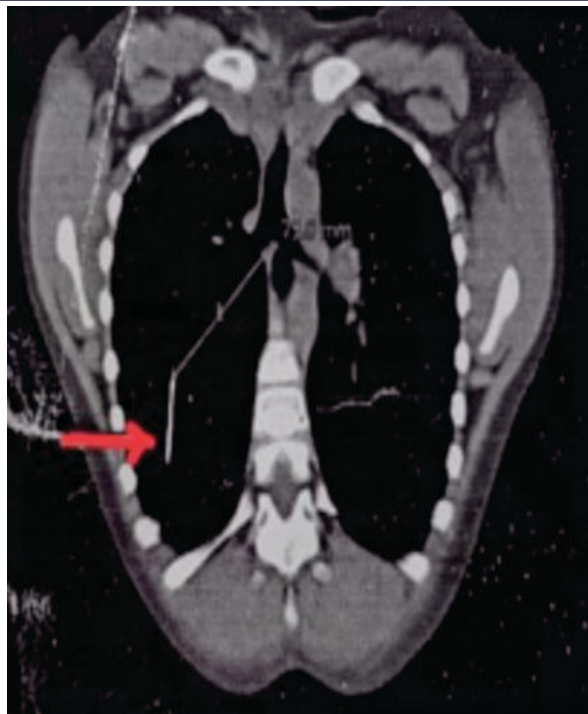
Arrow Demonstrates Needle In Right Lower Lobe Of Lung On HRCT Chest
